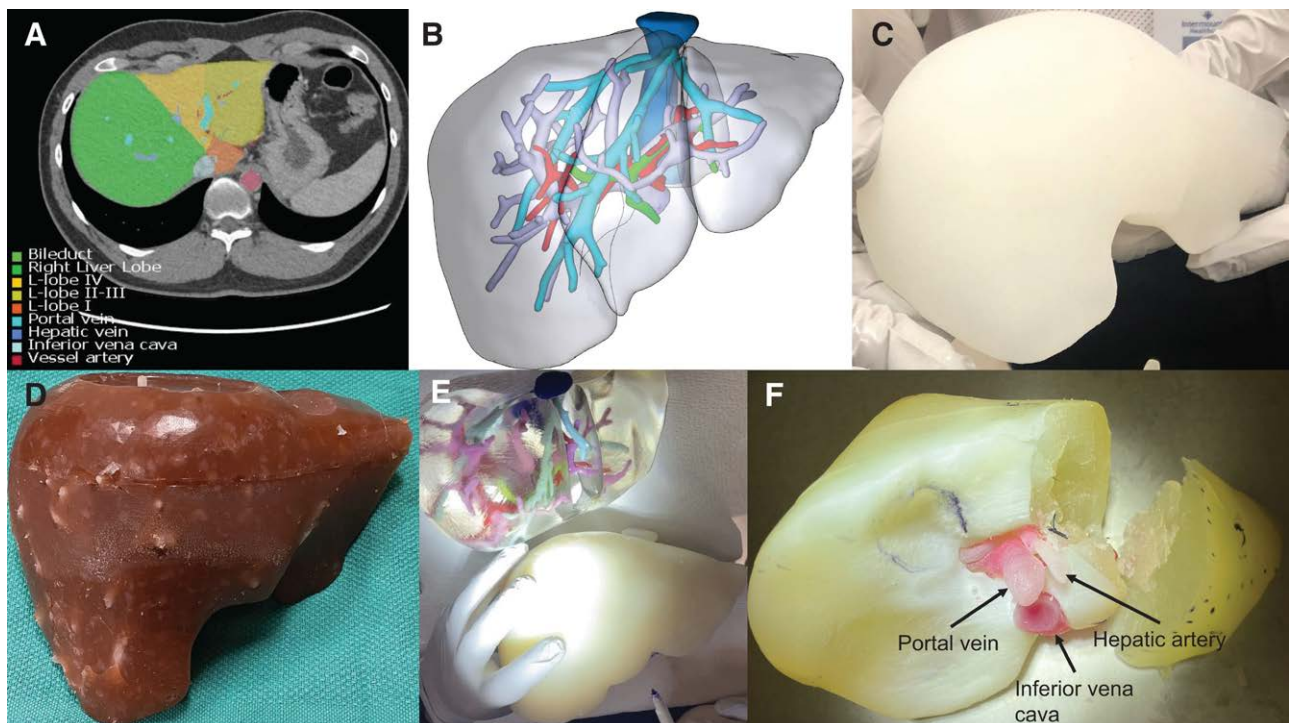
CT scan and volumes of the selected liver (A), 3-dimensional digital model (B), silicon hands-on model (C), organic gel hands-on model (D), 3-dimensional printed model for surgical planning along with the digital anatomy 3D printing hands-on liver model before (E), and after performing a left lateral sectionectomy (F). CT, computed tomography.
